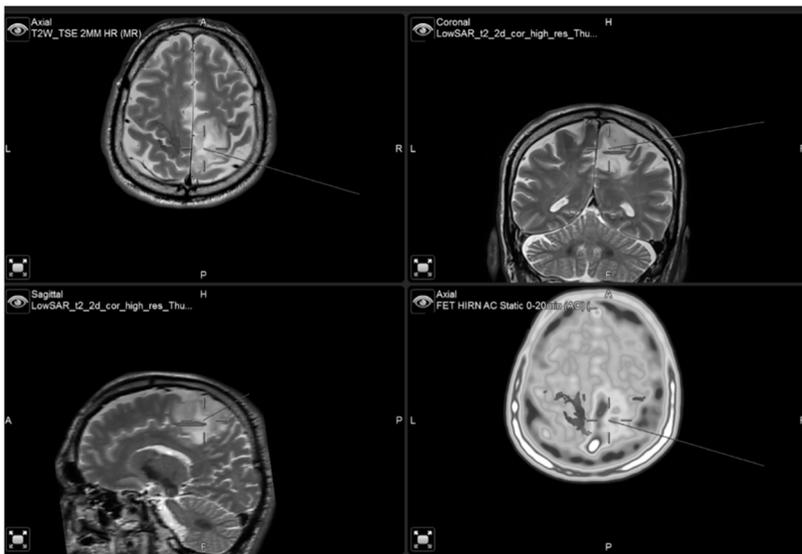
Intraoperative application of neuronavigation with multiple image data. Navigation-guided resection of a left parietal/postcentral glioma with non-significant contrast-enhancement with multiple image data including T2-weighted sequences, fiber tracking/diffusion tensor imaging and positron emission tomography (*right below*).
